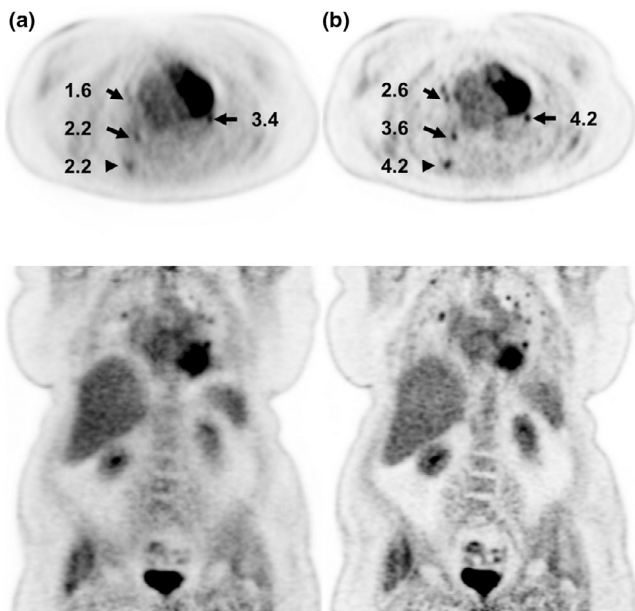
Patient images from a 76-year-old female (BMI = 42) with injection activity of 429 MBq (11.6 mCi) and uptake time of 64 min. Images are reconstructed without (a) and with (b) time-of-flight (TOF) correction with 3 min per bed. Numbers indicate lesion standardized uptake value (SUV).
